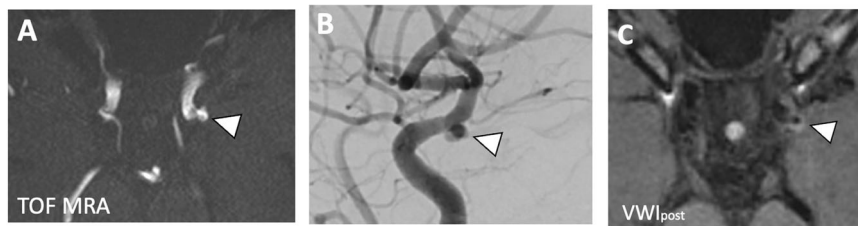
An approx. 30-year-old woman with subarachnoid hemorrhage with a left internal carotid artery aneurysm. A TOF MRA shows the aneurysm (arrowhead). B A catheter cerebral angiogram confirmed the aneurysm finding (arrowhead). C Postcontrast vessel wall MR imaging showed a rim of aneurysmal dome enhancement on postcontrast vessel wall MR imaging (arrowhead)
